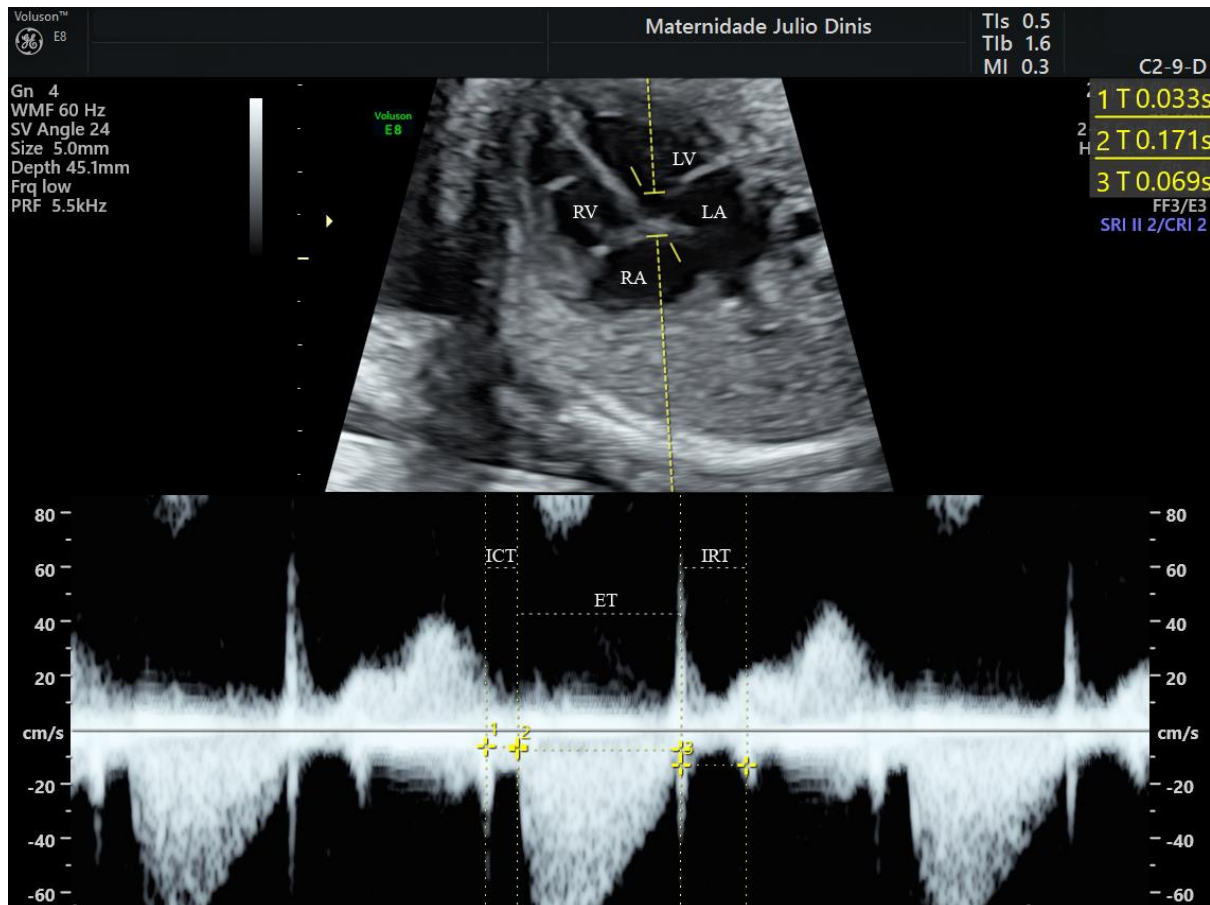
Mod-MPI Doppler waveform, showing the time intervals (ICT, IRT and ET).
